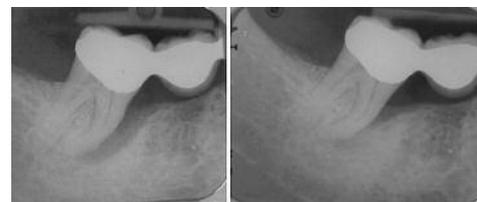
Pre- and post-NSPT periapical radiograph of tooth LR7 (case from Figure 1, treated by the author). The second radiograph was taken 12 months after NSPT and shows considerable bone fill in the defect
